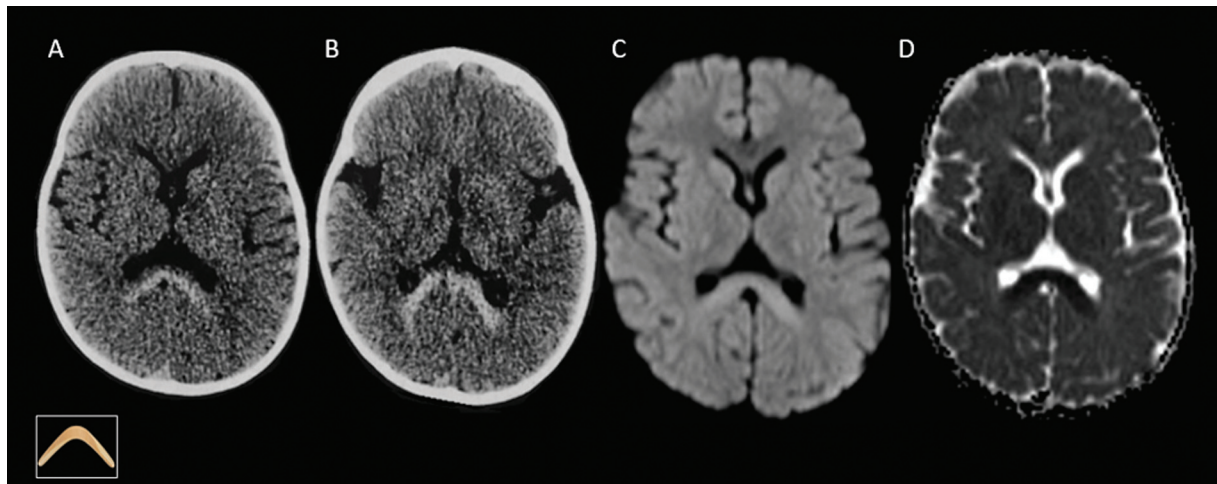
Brain computed tomography (CT) and magnetic resonance imaging (MRI) scans revealing hyperdensity (A,B) and restricted diffusion (C,D) in the splenium of the corpus callosum.
